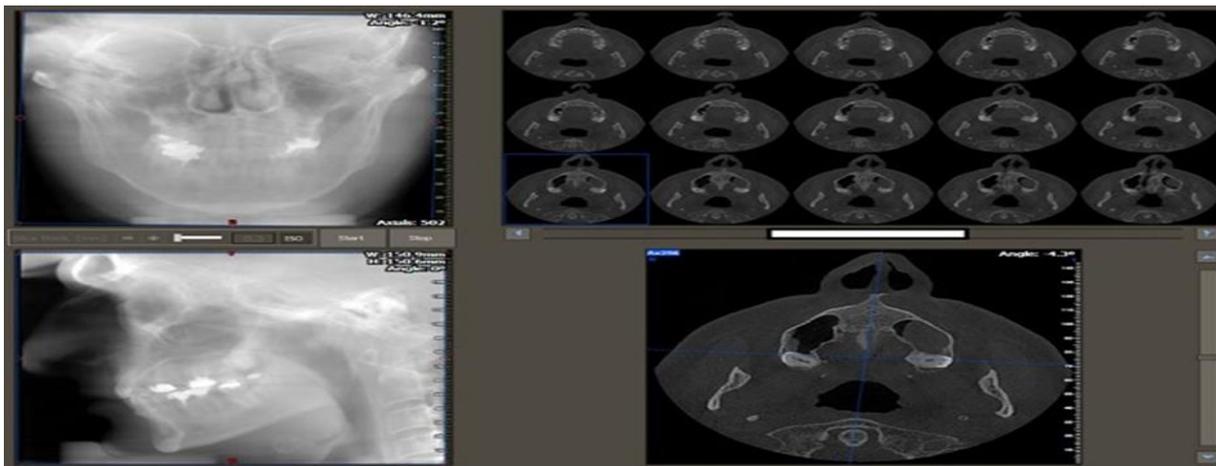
Correction of head deviations in CBCT volume to create a reformatted lateral cephalogram.
